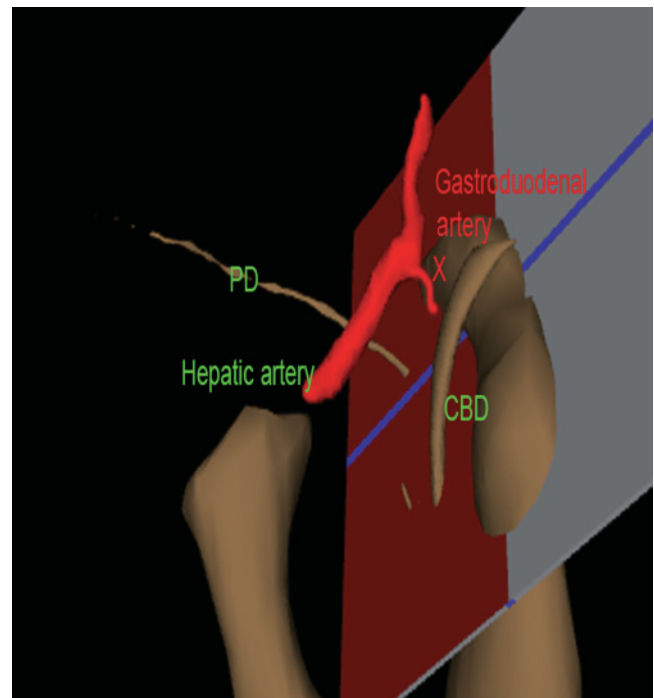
Visible Human Model with a plane that is in a location similar to what can be generated during linear array endoscopic ultrasound (EUS), showing the relative position of the gastroduodenal artery, pancreatic duct (PD), hepatic artery, and common bile duct (CBD).
